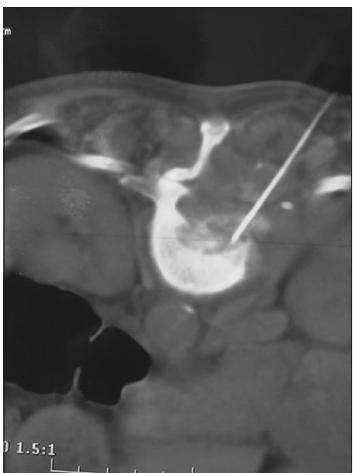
Computed tomography-guided fine-needle aspiration cytology of the T11 lesion suggestive of a granulomatous tubercular-like inflammation
